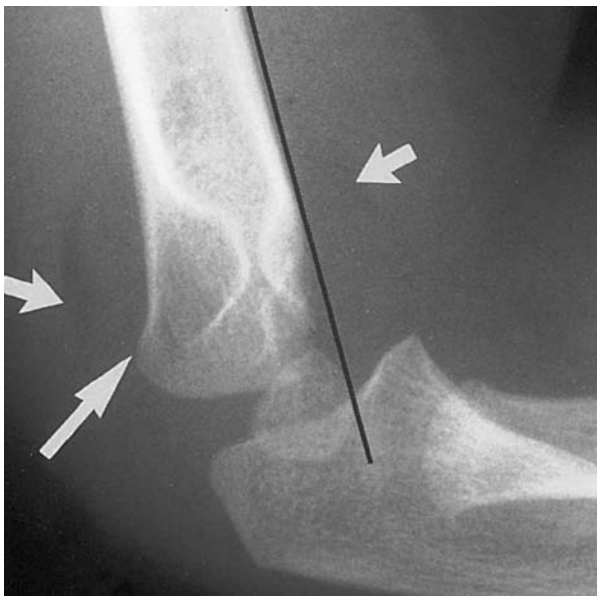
Lateral radiograph of the elbow of a 2-year-old girl. Once again, both the anterior and posterior fat pads are elevated (*small arrows*). In addition, the anterior humeral line passes along the anterior edge of the capitellum rather than through its center. Mild buckling of the posterior cortex of the distal humerus can be seen (*large arrow*).
